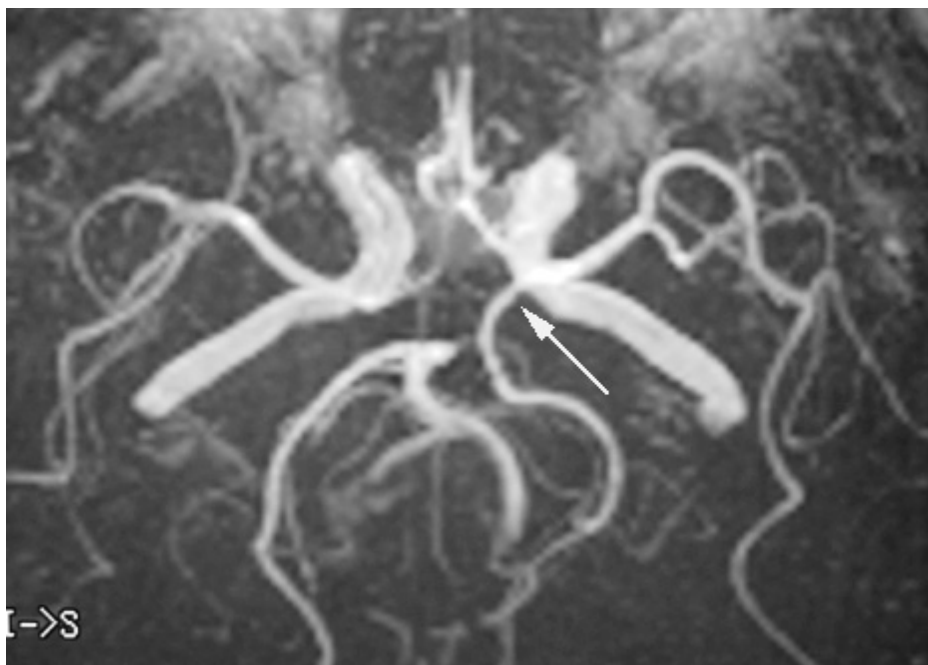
Anomalous origin of posterior cerebral artery MRI
